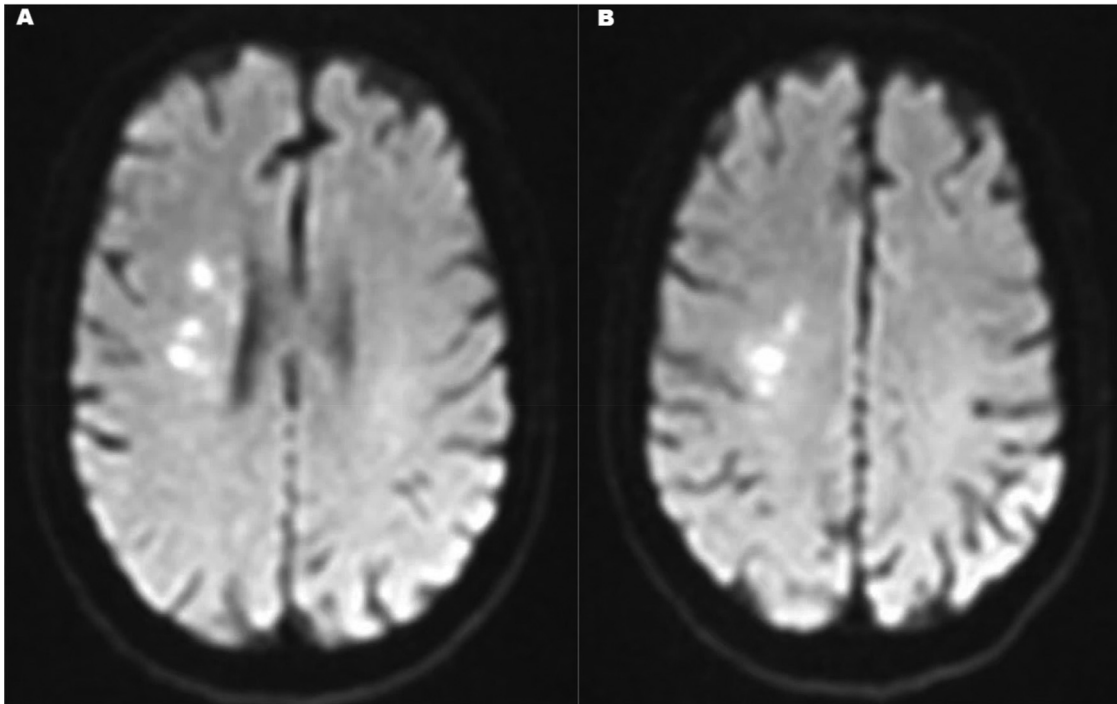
After repeated mechanical thrombectomy, diffusion-weighted imaging (DWI) shows a small infarct area.
